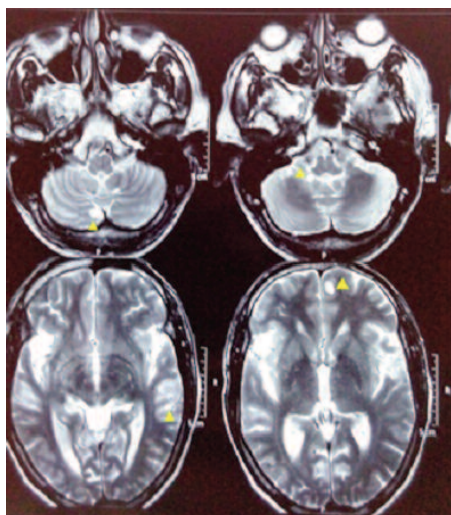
Magnetic resonance imaging Brain T2 weighted screening axial section showing multiple hyperintense lesions in left frontal and parietal and right cerebellar hemispheres (yellow arrowheads)
